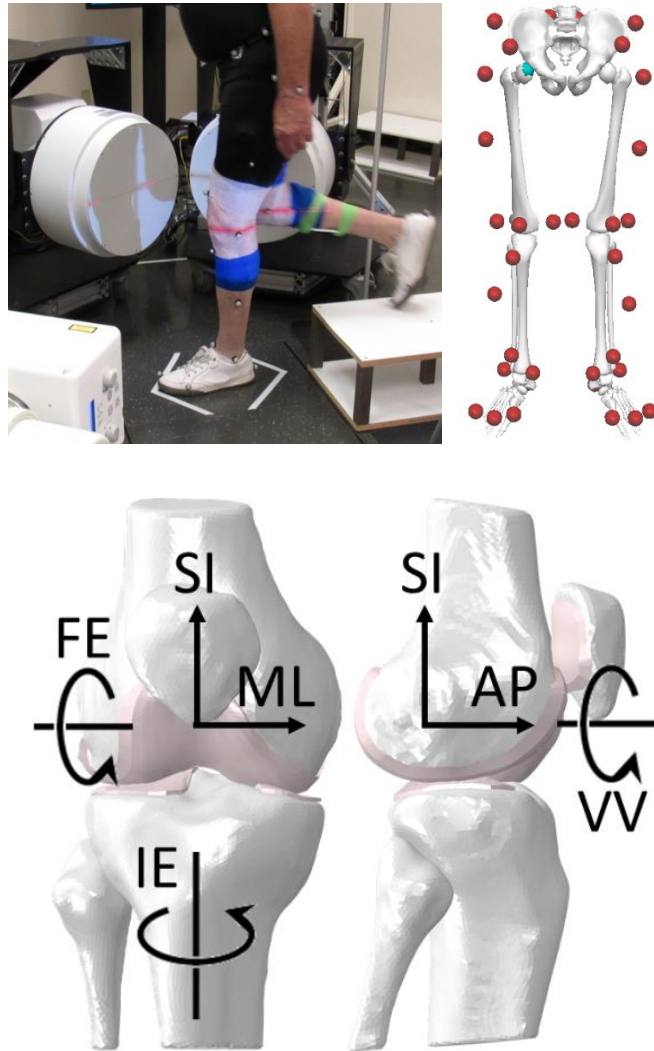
(top-left) Simultaneous biplane radiography and optical motion capture highlighting lower extremity marker set. (top-right) Experimental marker set. (bottom) Coordinate system used for resolution of knee kinematics.
